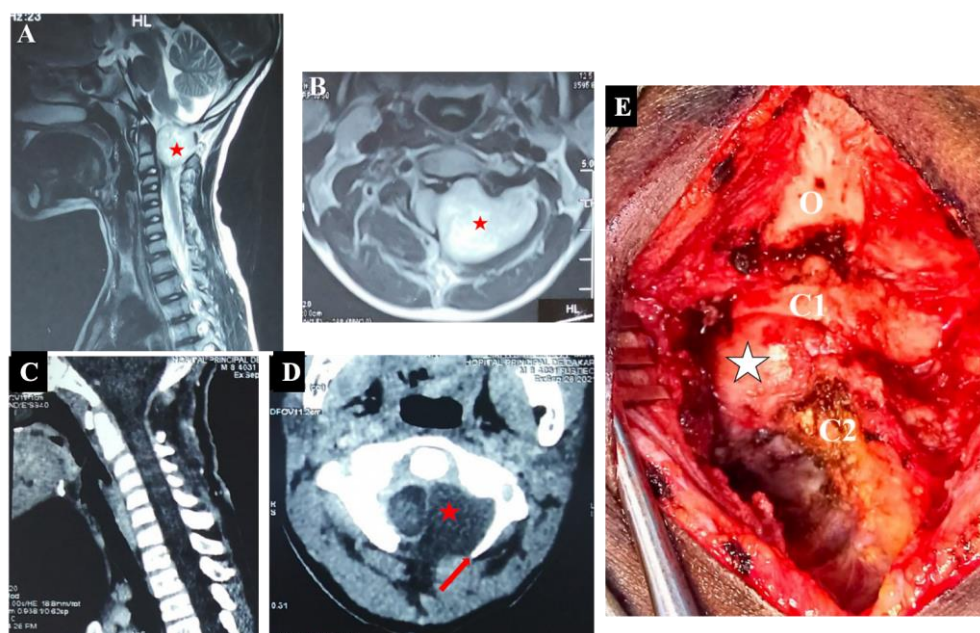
Preoperative MRI images of patient P7 objectifying a posterolateral tumor (red stars on A and B) and postoperative CT control showing a total excision by hemilaminectomy (red stars and arrow on C and D). Intraoperative view showing the tumor after posterior medial approach (white star on E).
